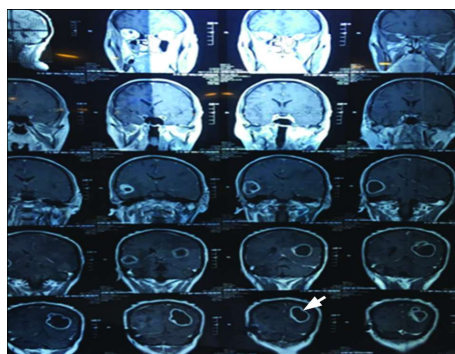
Post-contrast coronal MRI images showing lobulated mass lesions in left parietal and right temporal regions, measuring 4.8 cm AP x 4.1 cm MTD x 5.7 cm CC and 3.5 cm AP x 3.0 cm MTD x 3.7 cm CC, respectively. Craniotomy defect is noted in right parietal bone due to placement of VP shunt.
